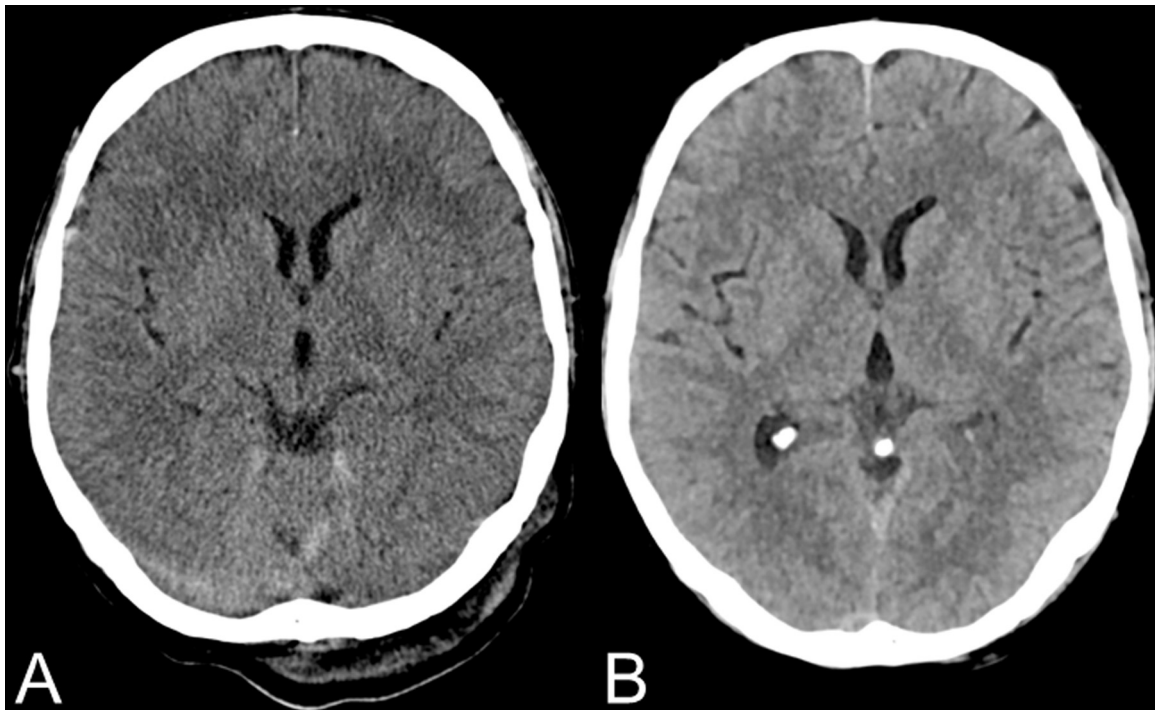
Intra-individual comparison between cranial CT in a sequential (A) and a spiral acquisition mode (B) (IR 5). IR 5 was rated best by both readers in all subjective evaluation parameters (B).
